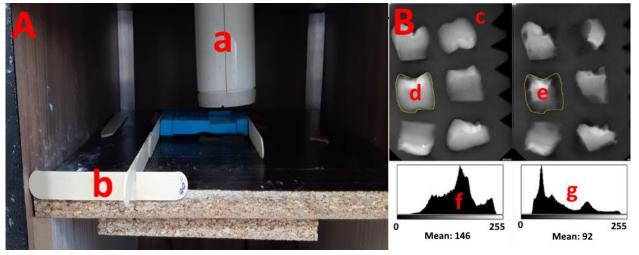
The irradiating tube at a fixed angle (A) and radiographs of the dental samples (B). The irradiating tube (a) was positioned at a fixed coordinate using the handmade holder (b) in a wooden box. The radiographs of the dental samples (already cast in silicon putty, c) were taken before and after the incubation period in the acidic condition. Using computer-assisted software, the area related to the dental samples was selected individually in the radiograph of the pre-incubated samples (d), and superimposed on the post-incubated samples (e). Subsequently, the geometric means of the graveral bistegrams of the pre-incubated for and post incubated samples (g) ware taken as the quantitative data.
